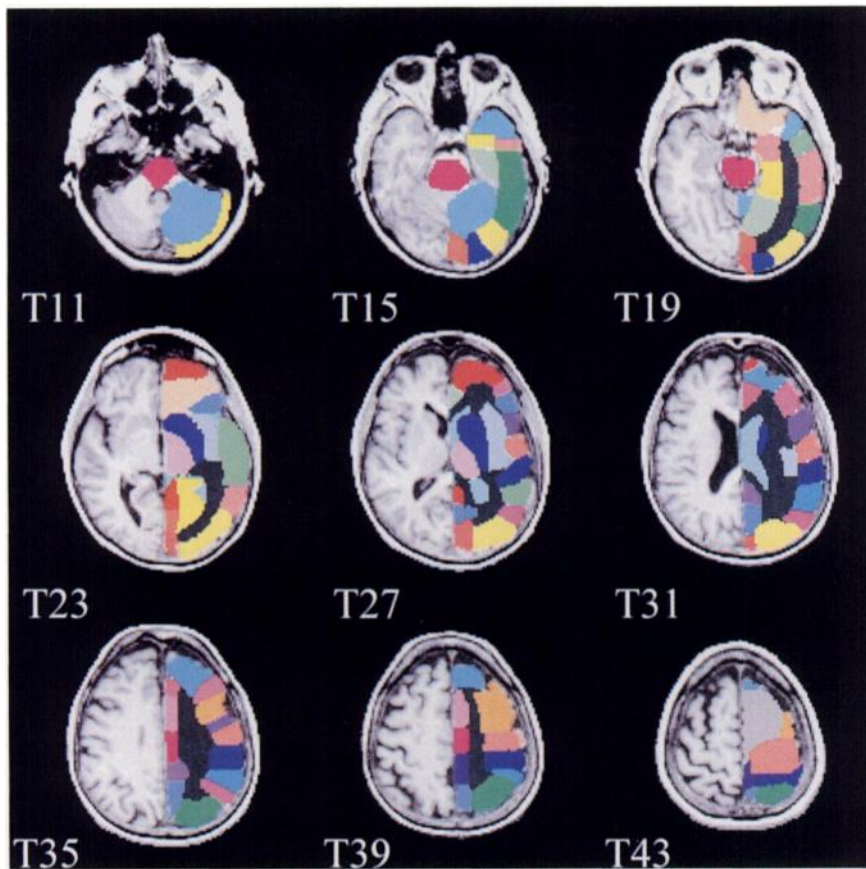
Representative axial slices through base MR image, with left ROI map superimposed. ROIs for right hemisphere were drawn separately and are similar to those for left hemisphere. Brain tissue is visible on slices 3–49 in modified MR image, and ROIs have been placed on slices 6–47. At lower left of each slice is slice number (2.66-mm slice thickness). Left-most slices in each row, from top to bottom, roughly correspond to the following in Talairach and Tournoux (20): 11–12a (–28 mm); 8–9a (+1 mm); 5–6 (+28 mm).
